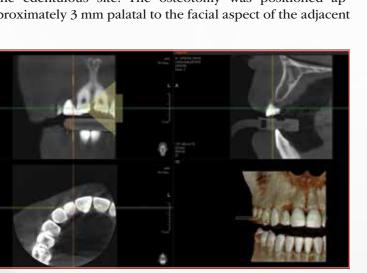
With CBCT technology, the quantity and quality of bone can be assessed digitally.
